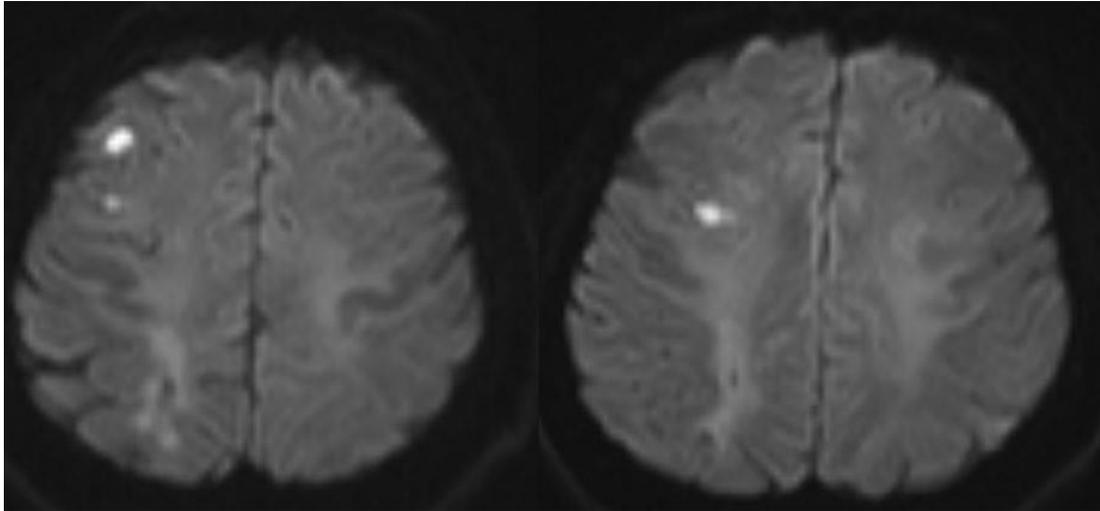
Watershed infarct on diffusion MR imaging
